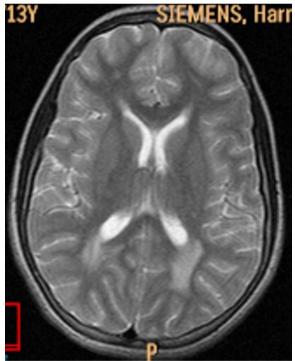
T2-weighted axial image showing ill-defined confluent hyperintensities in the bilateral supratentorial peri-ventricular, deep white matter regions.
